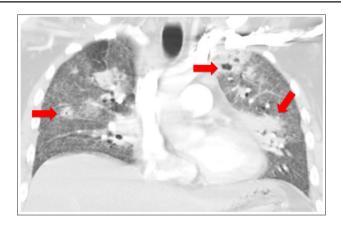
CT Chest Angiogram with Pulmonary Embolism protocol – coronal section
